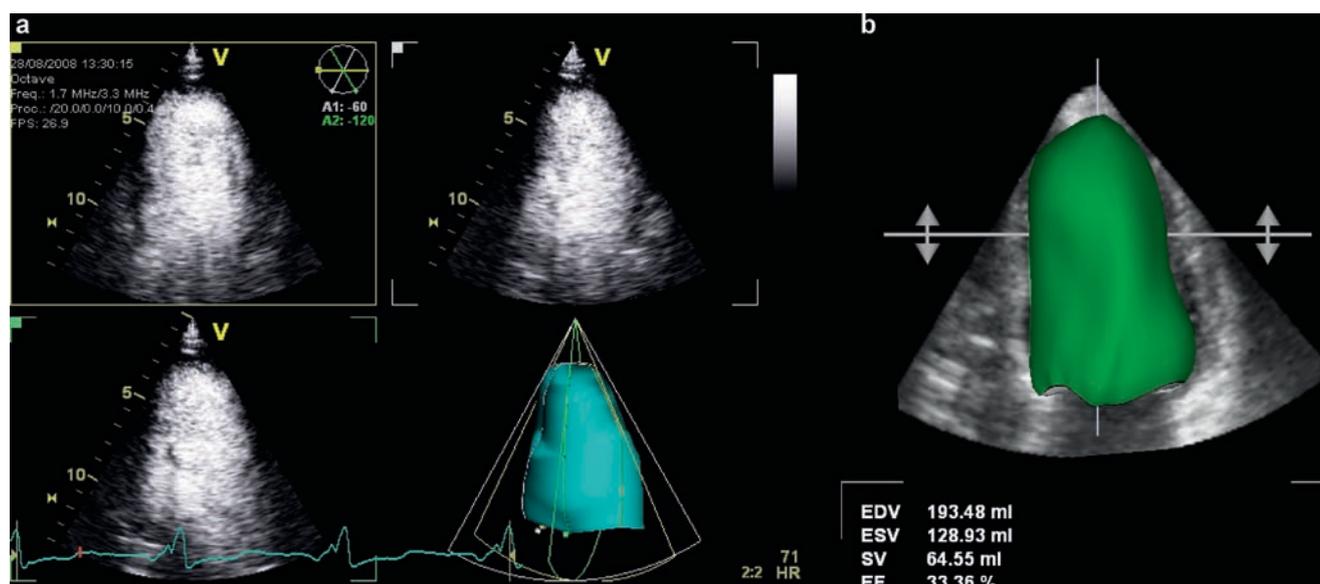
(a) Using tri-plane imaging, apical 2-, 3-, and 4-chamber views are acquired during one single heartbeat. With the use of manual tracing of the endocardial borders at end-systole and end-diastole, LV volumes are generated using the tri-plane method of discs. Note that intravenous contrast was used in this particular patient to
